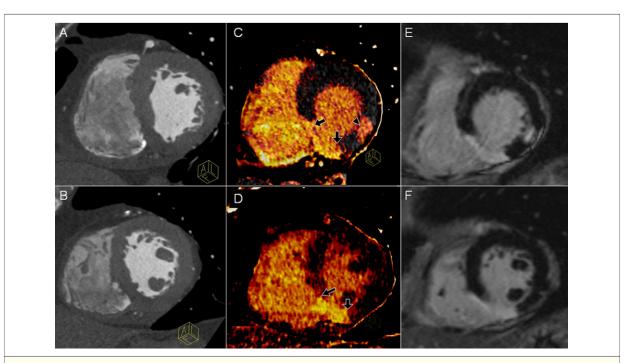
Myocardial Viability by Dual-Energy Computed Tomography and Comparison With CMR
